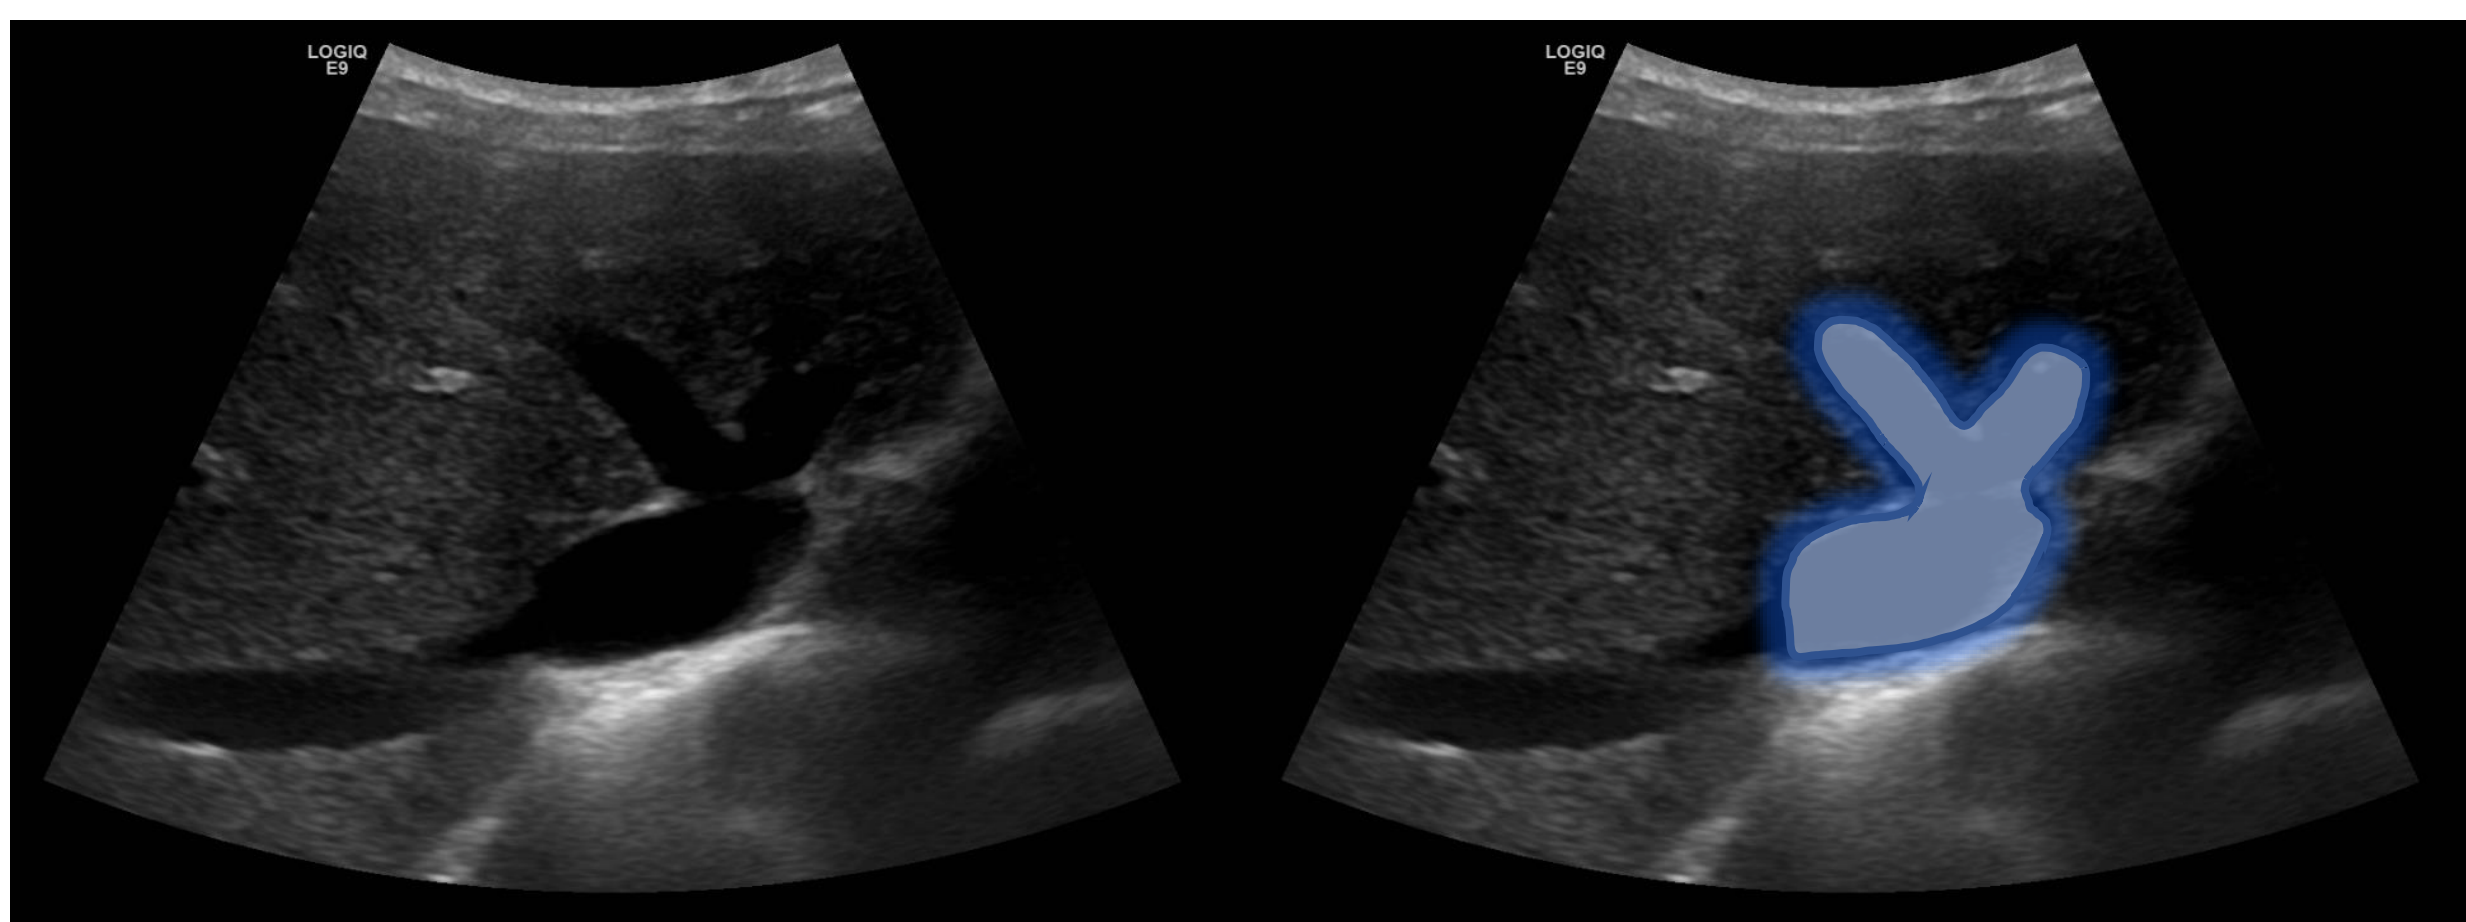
"Bunny sign" Ultrasound demonstrating the dilated IVC (head), mid hepatic vein (right ear) and left hepatic vein (left ear).
